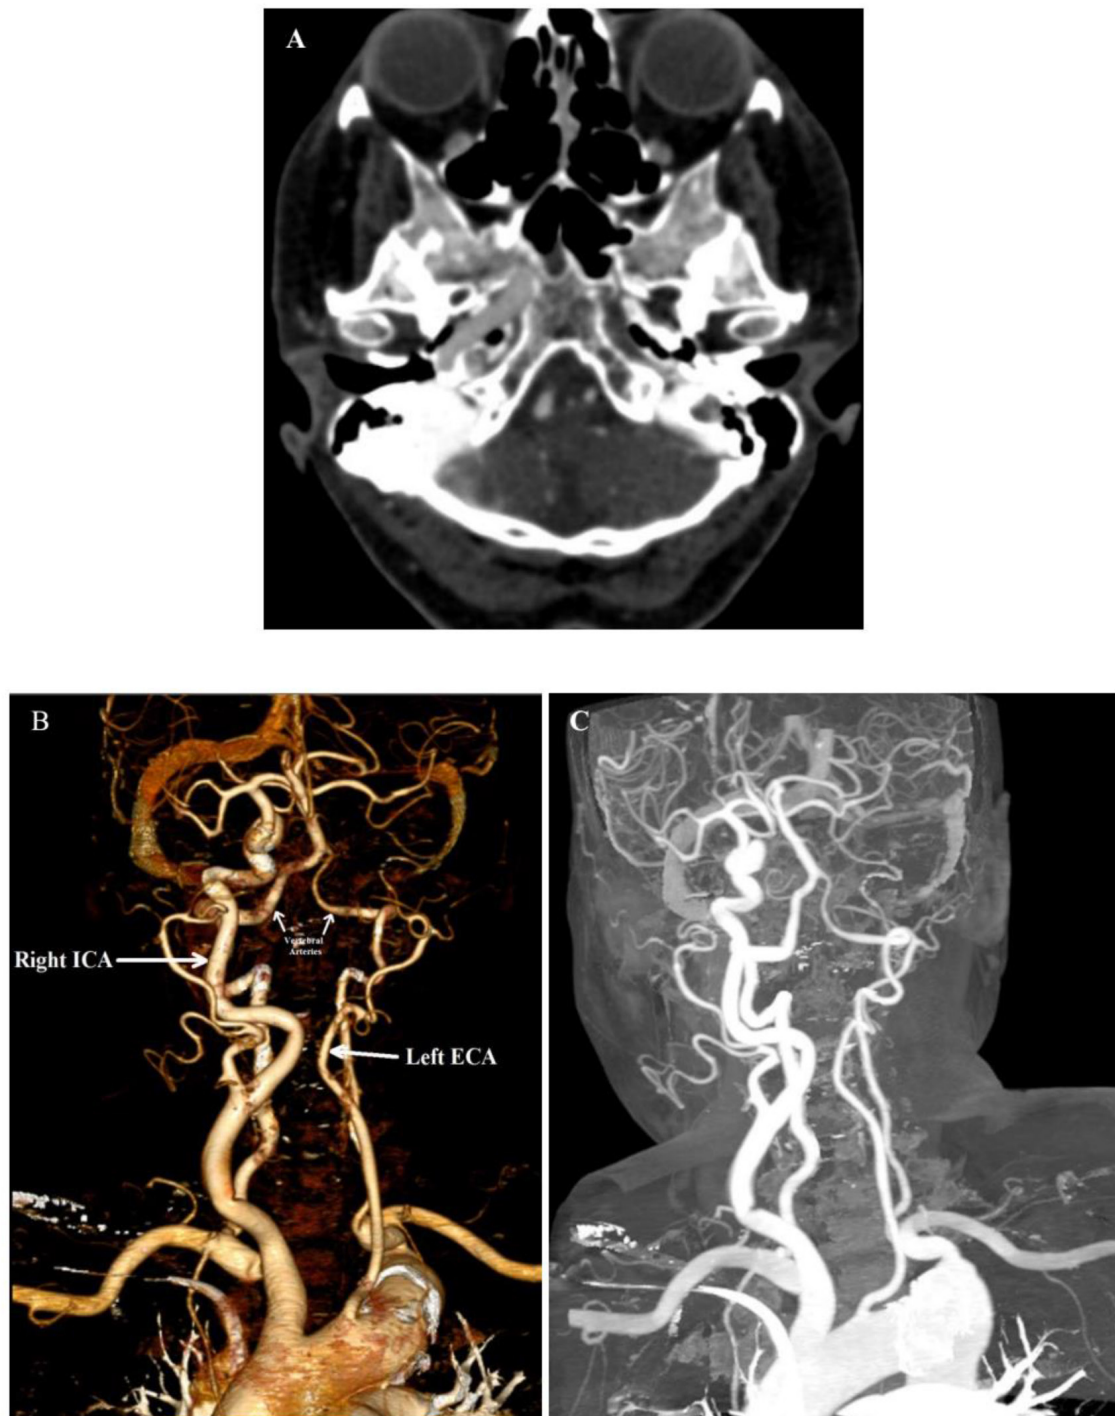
A: Axial CT angiography image at the level of skull base shows the absence of left ICA and left petrous carotid canal. B: Coronal volume rendered image and maximum intensity projection view of cranial vasculature (C) in case 2 revealed the absence of left ICA.
